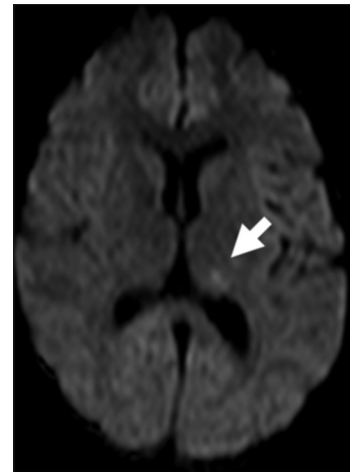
Magnetic resonance imaging scan of a woman presenting motor weakness in the right arm and leg at 26 gestational weeks on diffusion-weighted images shows a left thalamic infarction (arrow)
